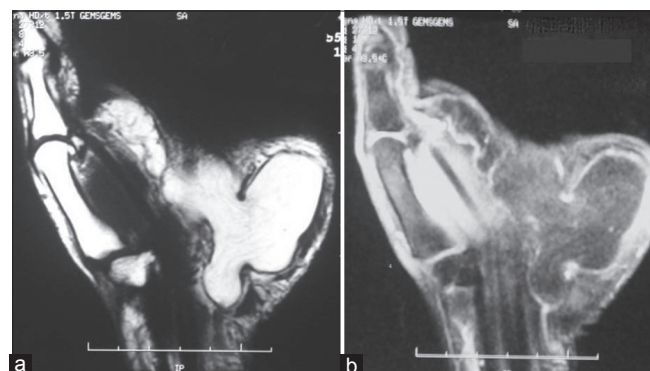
Magnetic resonance imaging finding of hyper-intense lesion in T1 (a) with short T1 inversion recovery suppression (b) in hypothenar space and Guyon's canal
